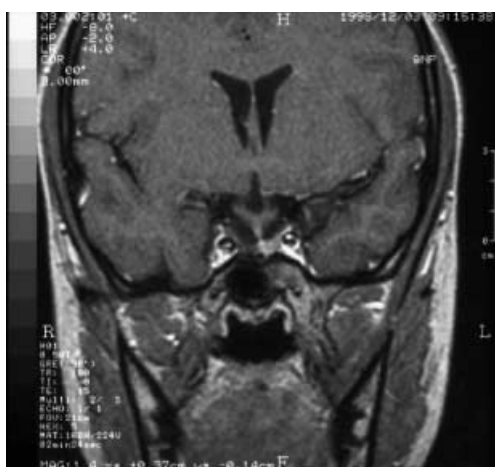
Coronal T1-weighted image after gadolinium (GDTPA) administration, 1 year after surgery: there is not any evidence of the preexisting tumor mass and the residual pituitary gland lies in the left portion of the sella
